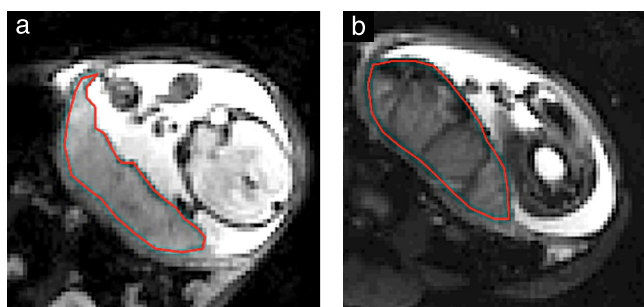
Placental T2*-weighted magnetic resonance images at 28 weeks' gestation, showing region of interest (red outline) in: (a) non-mosaic placenta (transverse relaxation time (T2*), 117 ms) and (b) mosaic placenta (T2*, 52 ms). Placentae are visually different, with that in (b) appearing larger and darker than that in (a).
